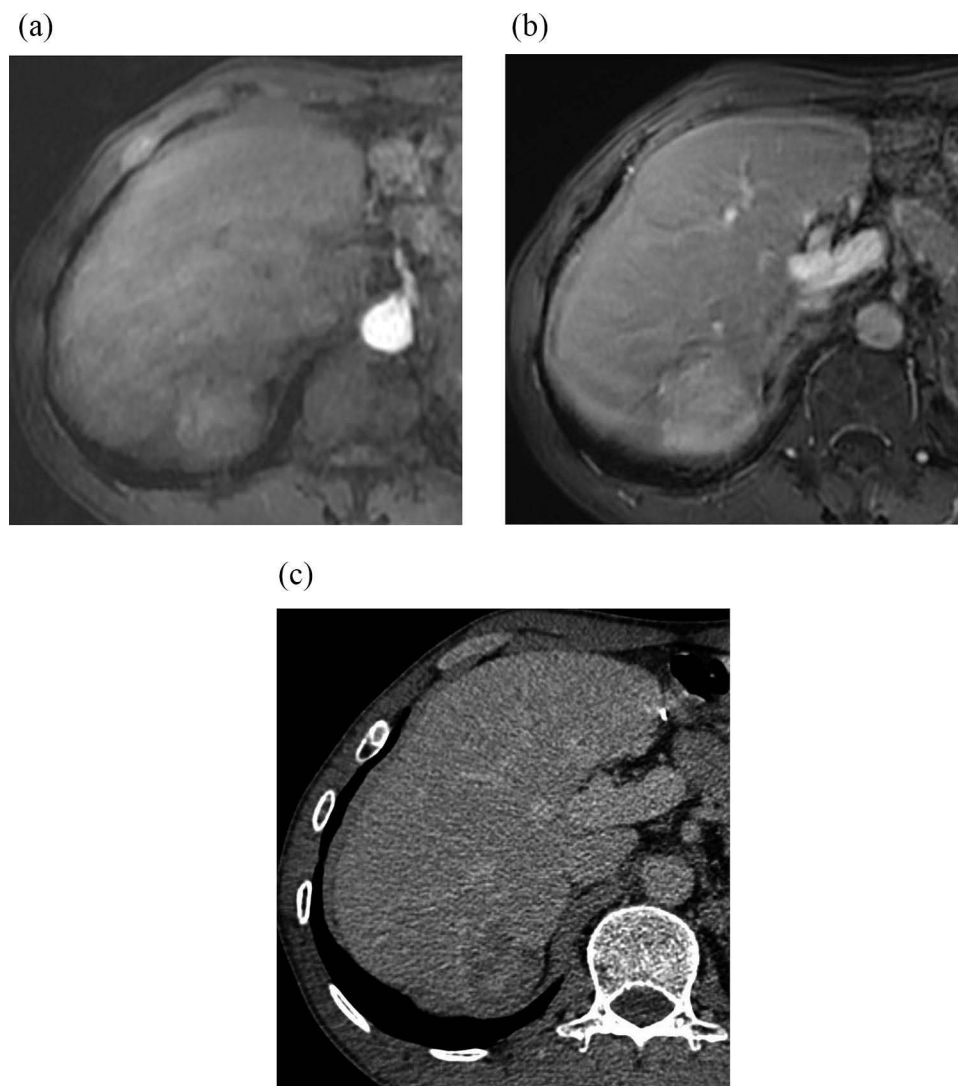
52-year-old man with cirrhosis and HCC. Figure (a) shows APHE of Gd-EOB-DTPA MRI. Figure (b) shows no washout and no capsule in PVP of Gd-EOB-DTPA MRI. Tumor diameter > 2cm, and LR-4. Figure (c) shows washout and enhancing capsule in delayed phase of CT. Adding CT delayed-phase images to Gd-EOB-DTPA MRI, the lesion was classified as LR-5.
